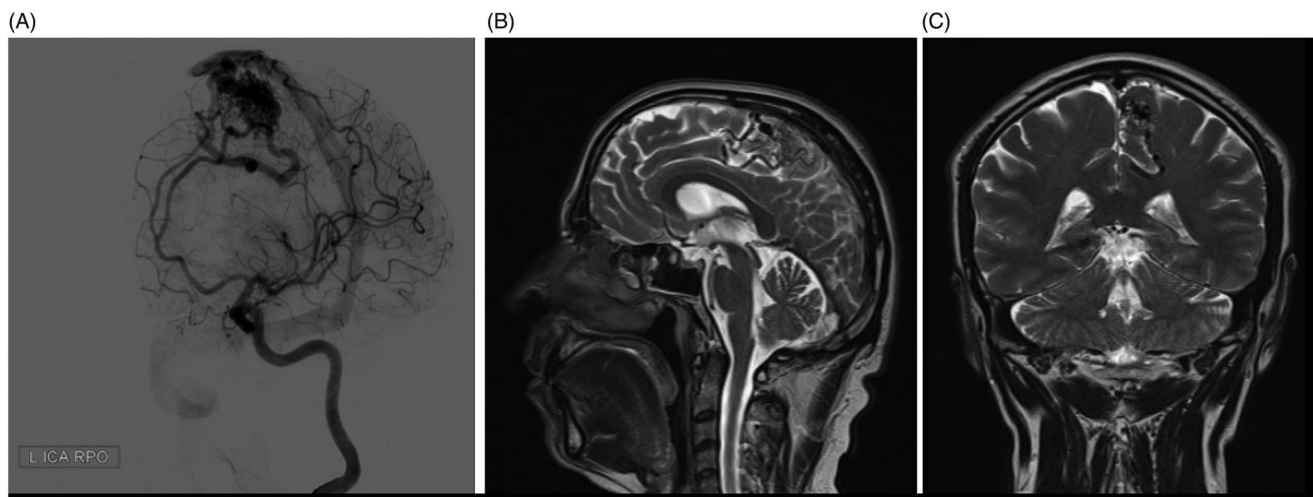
Digital subtraction angiography (DSA) (A) and cranial MRI (B, C) of the AVM in the left parietal lobe before the radiosurgery.
